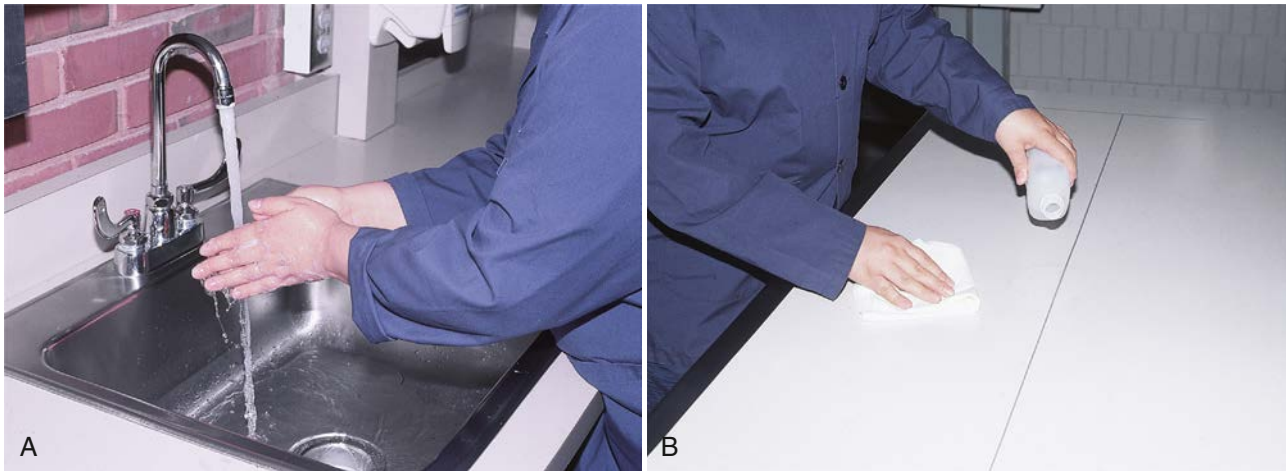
(A) Radiographers should practice scrupulous cleanliness, which includes regular handwashing. (B) Radiographic tables and equipment should be cleaned with a disinfectant according to department policy.
